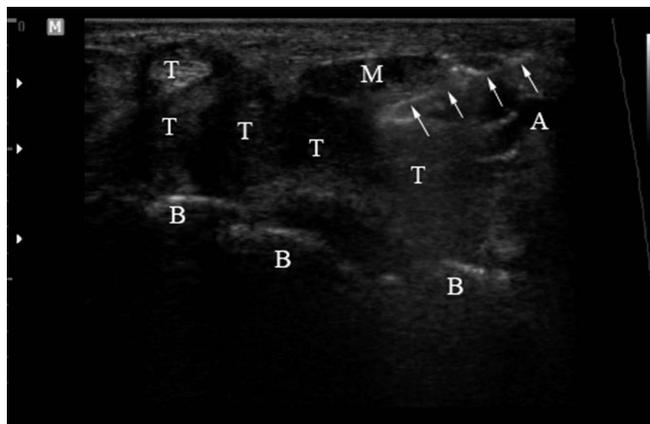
Ultrasound-guided carpal tunnel syndrome (CTS) injection in transverse (short axis) view. M, median nerve; T, tendons; B, metacarpal bones; A, ulnar artery; White arrows, needle.
